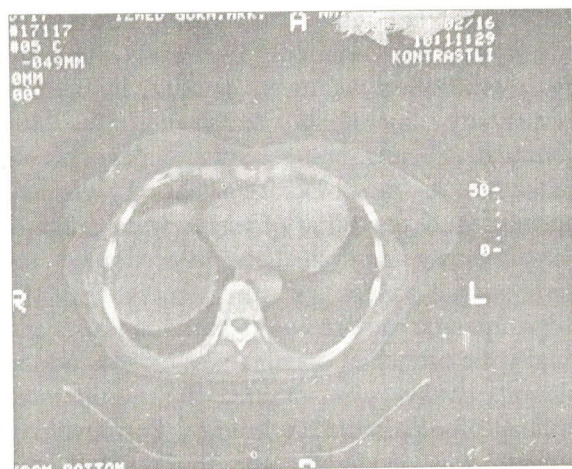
Computed tomography of the abdomen shows the dome located liver hydatid cyst which is 15 cm in diameter.
